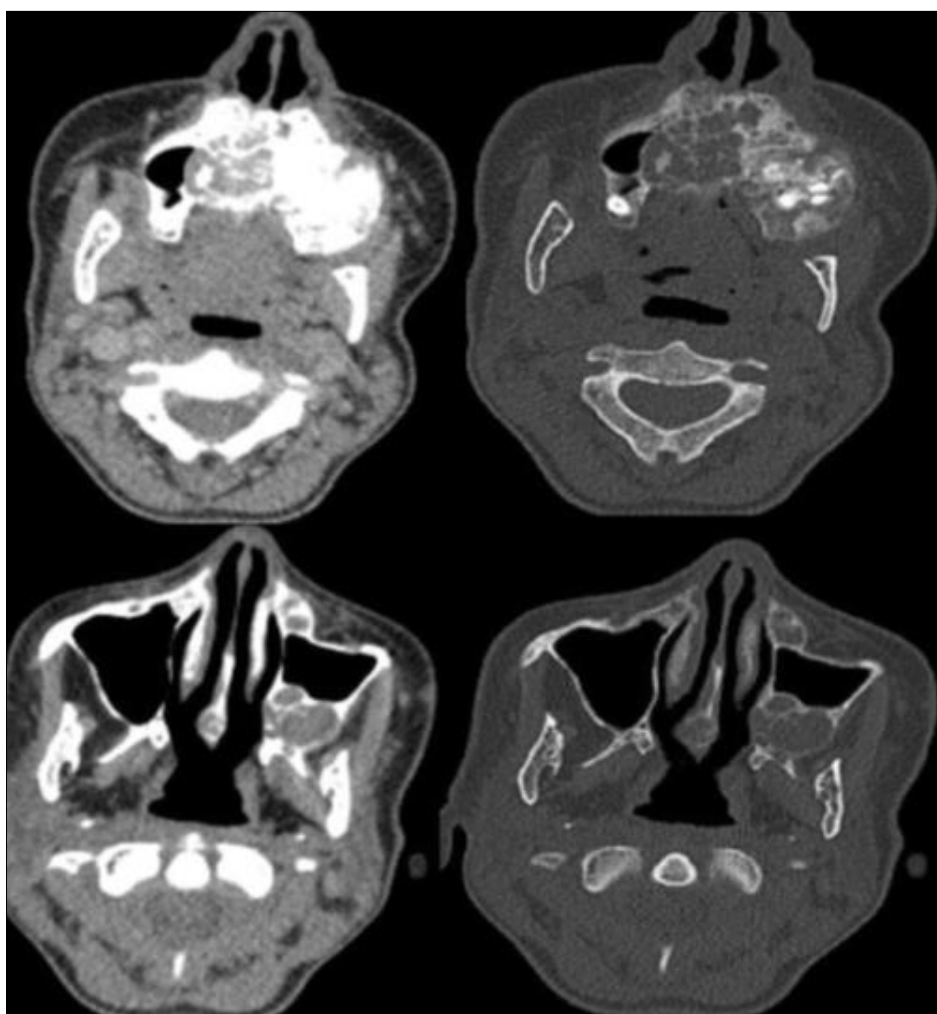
Axial CT scan with soft tissue and bone window settings
